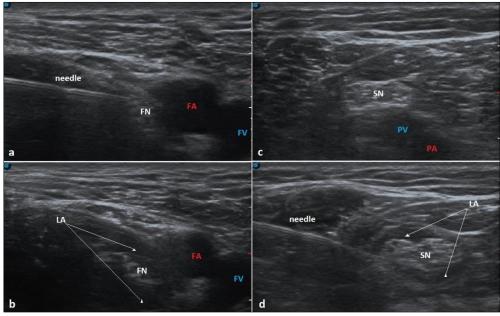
(a) Ultrasound image of the femoral nerve in the inguinal region before injection of local anaesthetics. (b) Ultrasound image after femoral nerve block: diffusion of local anaesthetics around the femoral nerve. (c) Ultrasound image of the sciatic nerve in the popliteal region before injection of local anaesthetics. (d) Ultrasound image after sciatic nerve block: diffusion of local anaesthetics around the sciatic nerve. FN = femoral nerve, FA = femoral artery, FV = femoral vein, SN = sciatic nerve, PA = popliteal artery, PV = popliteal vein, LA = local anaesthetics.
